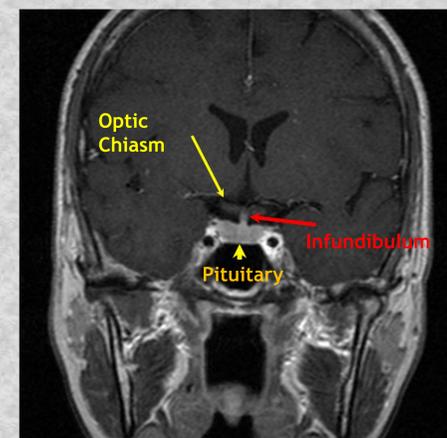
Coronal MRI view, demonstrating normal pituitary gland anatomy.⁵
